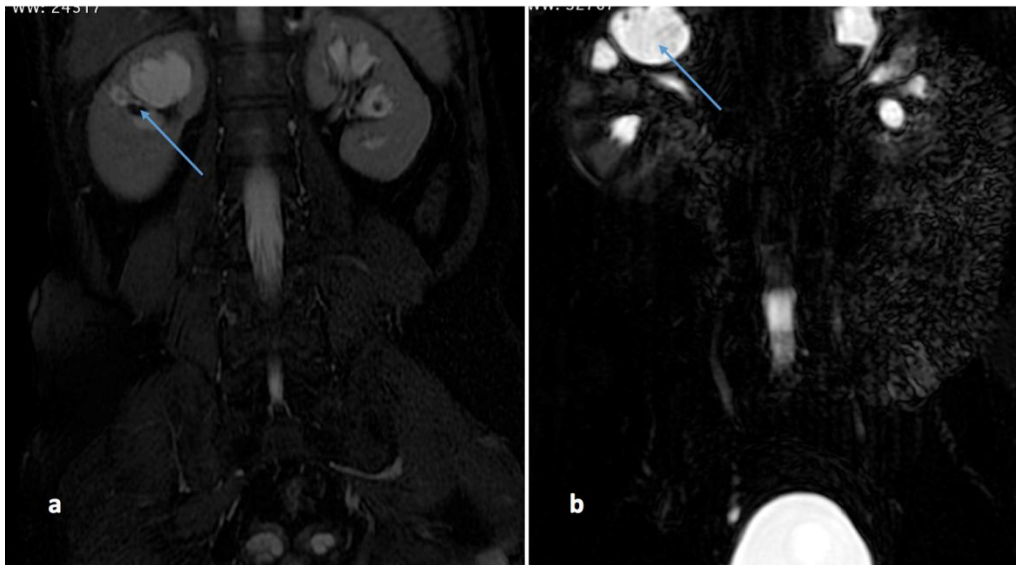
2 A case of right renal case. MRI COR. T2WI (A) shows calculus seen as signal void in PUJ and upper pole of Right Kidney. 3D urogram (B) showing Right sided hydronephrosis.
